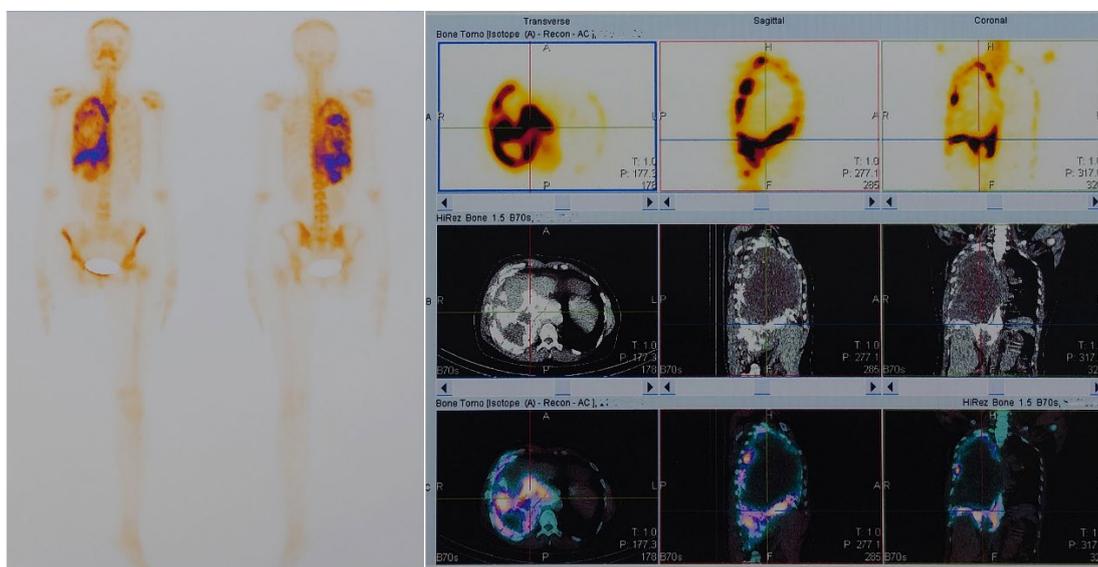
Planar bone scan and Chest SPECT CT revealing pleural based calcified mass with intense ^{99m}Tc -MDP accumulation.
